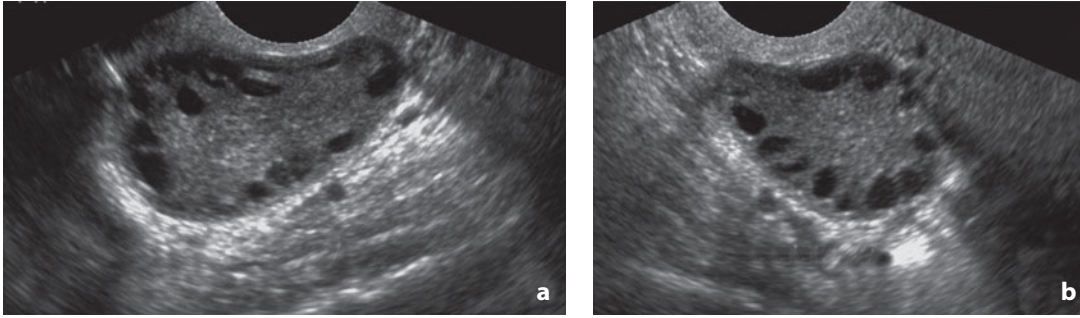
Transabdominal ultrasonography. Polycystic ovary. Both ovaries appear enlarged with multiple small anechoic cystic formations situated on the ovarian surface
